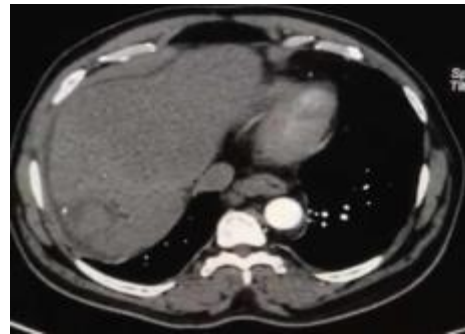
Triphasic CT shows complete remission of HCC lesion after TACE with aspirin (previous microwave ablation noted in lower image).
